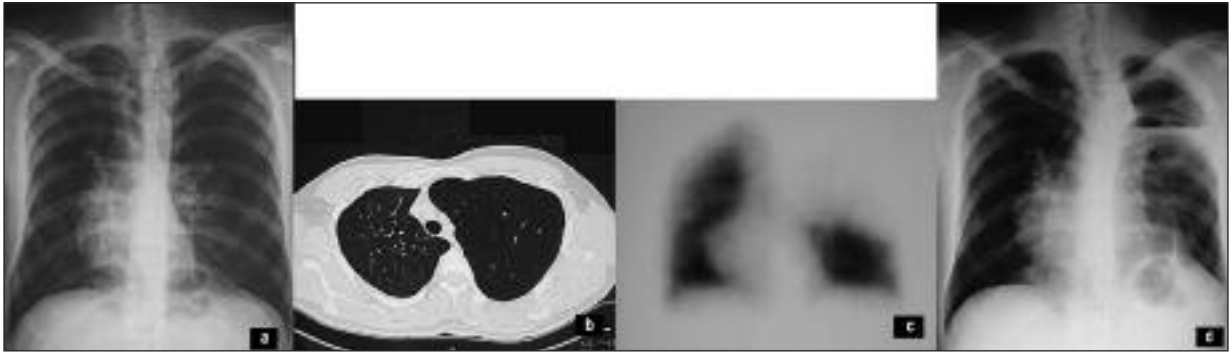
Hyperlucency on the upper zone of the left hemithorax and mediastinal shift to the right side in preoperative chest x-ray (1a); hyperinflation of the left upper lobe, shift of the mediastinal structures to the right side and diminished anterior posterior diameter of the chest on CT (1b); decreased perfusion in the involved lobe (1c); the left lower lobe filled only 2/3 of the hemithorax in the postoperative third month chest x-ray (1d).
